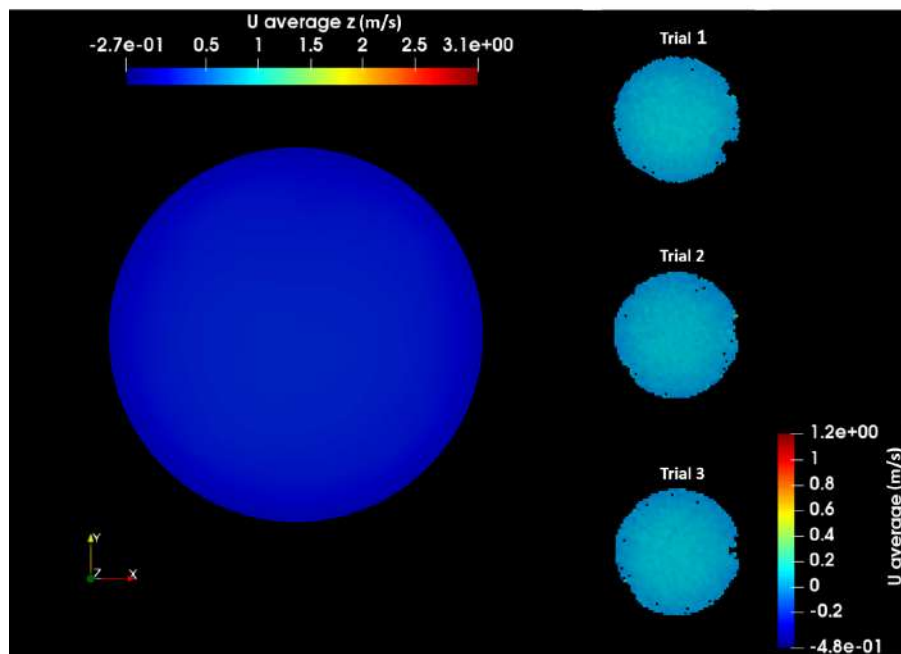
Comparison of CFD and 2D PC-MRI velocity distribution in the inlet slice of the pharynx model during inspiration.
